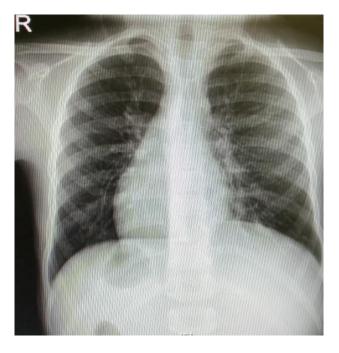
Chest radiograph showing the cardiac apex in the right hemithorax with the gastric bubble visible in the right upper quadrant.
